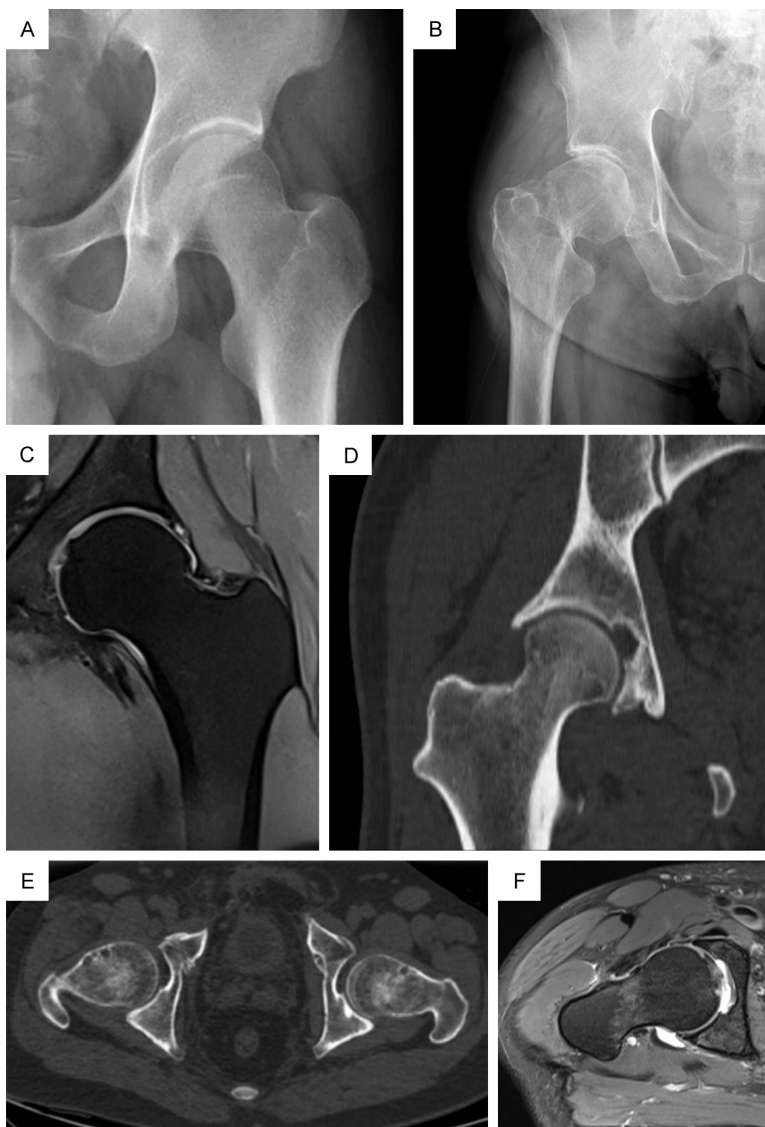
Representative MRI imaging findings. A. X-ray image of a normal hip joint showing preserved structure and normal joint space. B. X-ray image of a hip joint with abnormal bone hyperplasia and joint space alterations. C. 3D CT reconstruction of a control subject showing normal acetabular morphology and femoral head coverage. D. 3D CT reconstruction of a FAI patient clearly showing cam-type deformity of the femoral head. E. MRI of a control subject showing normal signal and intact soft tissues, including articular cartilage and acetabular labrum. F. MRI of a FAI patient showing typical soft tissue lesions caused by impingement, including labral tears and cartilage damage. Note: MRI, magnetic resonance imaging; FAI, femoroacetabular impingement; CT, computed tomography; 3D, three-Dimensional.
